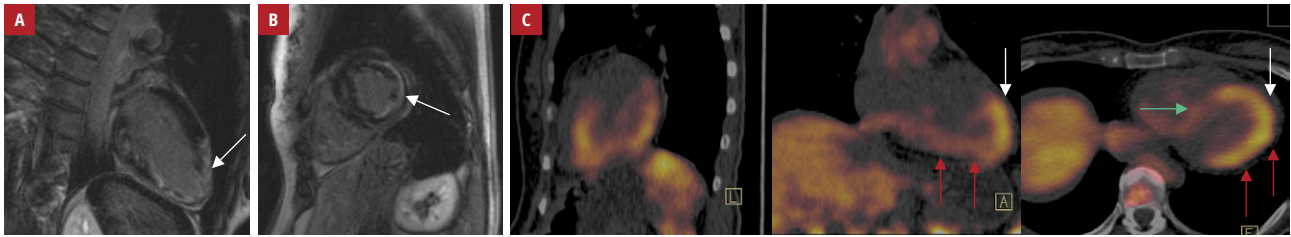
A, B – cardiac magnetic resonance images with late enhancement techniques; A – the long-axis 2-chamber view demonstrating subepicardial and mid-wall late gadolinium enhancement in the left ventricular wall (arrow); B – the short-axis demonstrating diffuse areas of late gadolinium enhancement representing bands of increased signal running in the short axis plane (arrow); C – fusion positron emission tomography images (sagittal, coronal, and axial presentation, left, middle, and right, respectively) of myocardial 18F-2-fluoro-2-deoxy-D-glucose uptake showing the area of high preferential glucose uptake in the apex (white arrows), lateral and postero-lateral walls (red arrows). High 18F-2-fluoro-2-deoxy-D-glucose uptake area corresponds with the decreased single-photon emission computed tomography perfusion area (Supplementary material, *Figure S1*). Green arrow shows low septal 18F-2-fluoro-2-deoxy-D-glucose uptake, corresponding with normal single-photon emission computed tomography perfusion.
